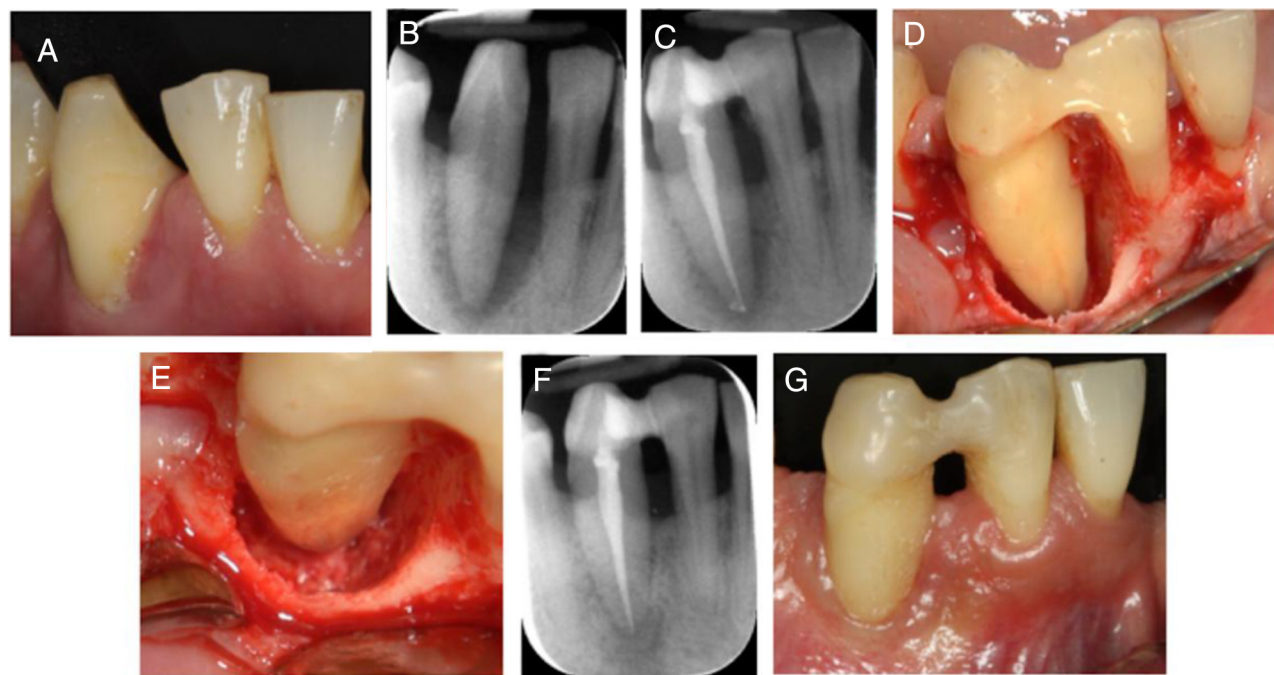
Case 1. (A) The buccal view of the tooth with 5-mm gingival recession, bleeding, and inflammation. (B) The baseline radiograph showing bone destruction beyond the apex of tooth #27. (C) The postendodontic radiograph showing a reduction of the bone defect. (D) The granulation tissue was removed and the root shaped. (E) Three-wall bone defect. (F) The 14-month follow-up radiograph showing resolution of the bone defect. (G) The presence of healthy soft tissues.
